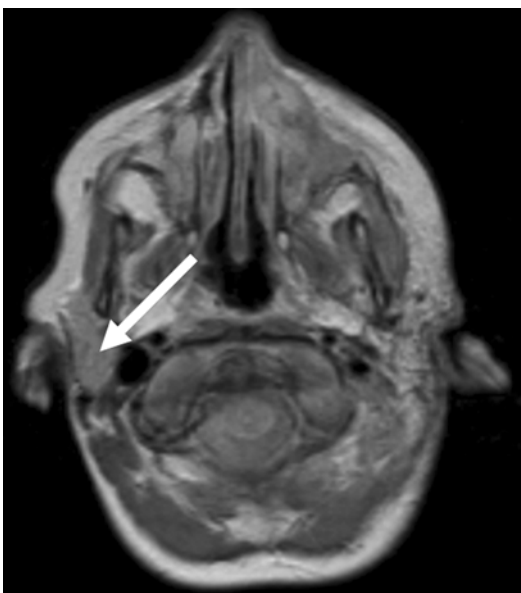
Coronal magnetic resonance image showing a secondary malignancy (sarcoma indicated by *arrow*) in a patient treated for retinoblastoma
